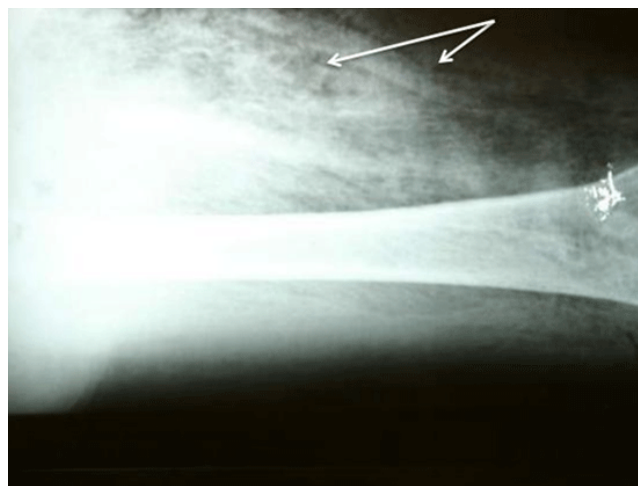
Plain radiograph of the right thigh. Arrows show subcutaneous gas from gas-forming organism
